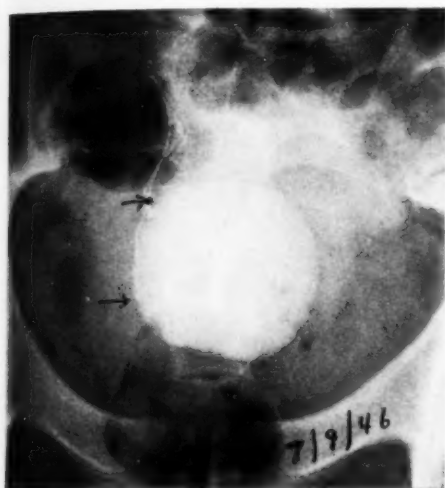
Case 6. To outline the tumor for radiographic study, a tantalum wire was sewed, in purse-string fashion, around the periphery of the tumor (between two arrows). The ends of the wire extended out through the suprapubic opening. Note the excellent apposition to the surface of the balloon.
